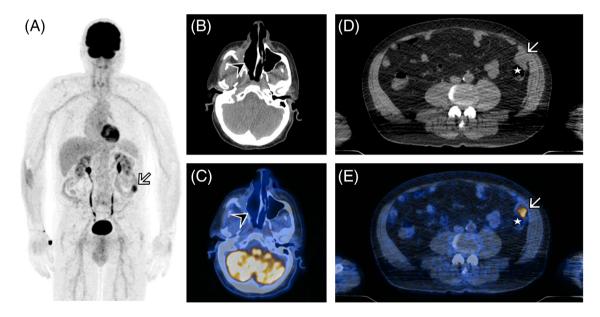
FDG-PET/CT restaging examination of a 67-year-old man with maxillary sinus squamous cell carcinoma after surgical tumor resection and adjuvant radiation therapy: (A) whole-body maximum intensity projection of PET shows a metabolically active tumor in the left-sided abdomen (white arrow). (B) nonenhanced CT and (C) axial fused FDG-PET/CT show no evidence of local recurrence of the sinonasal tumor (arrowhead), (D) nonenhanced CT and (E) axial fused FDG-FDG-PET/CT demonstrate a metabolically active tumor in the small bowel (white arrow), located anterior to the descending colon (white asterisk). This incidental finding turned out to be follicular lymphoma. CT, computed tomography; FDG-PET/CT, 2-[¹⁸F]-fluorodeoxy-D-glucose positron emission tomography/computed tomography [Color figure can be viewed at wileyonlinelibrary.com]
